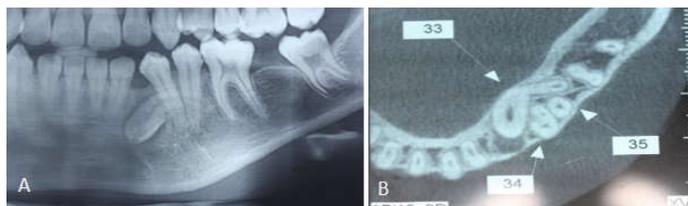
Imaging exams. A: panoramic radiography. B: axial section of cone beam computed tomography
